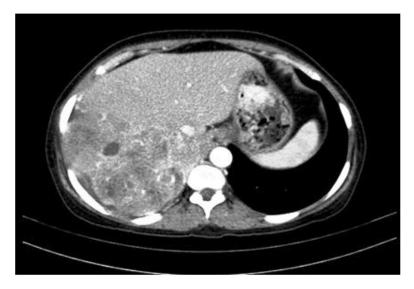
Computed tomography showing synovial sarcoma involving the right lung with heterogeneous enhancement, having both solid and cystic components and prominent vascular structures within the solid component.
